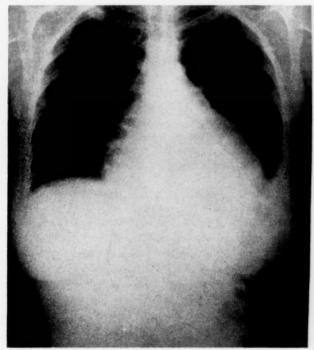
Roentgenogram taken on September 26, 1955, showing pericardial effusion and pleural effusion.
